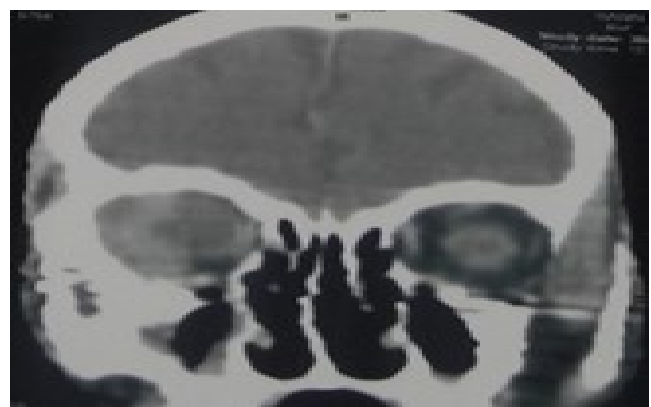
Coronal view of skull computed tomography. The right orbit is replaced by a homogeneous structure, unlike on the left side.
